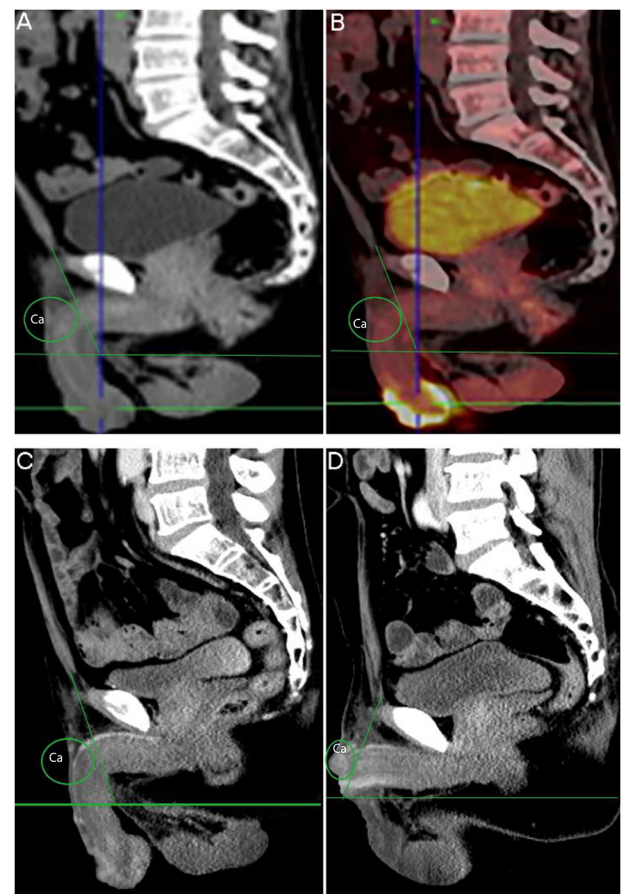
Case 2 (55-year-old). (A) Sagittal non-enhanced CT indicated multiple penile carcinomatous foci before partial penectomy (green circle indicates multiple penile carcinomatous foci). (B) Positron emission tomography/CT indicated multiple penile carcinomatous foci before partial penectomy (green circle indicates multiple penile carcinomatous foci). (C) Sagittal enhanced CT indicated multiple penile carcinomatous foci before partial penectomy (green circle indicates multiple penile carcinomatous foci). (D) Sagittal enhanced CT indicated recurrent cancer of the penile stump after partial penectomy (multiple penile carcinomatous foci were observed in the green circled area).
